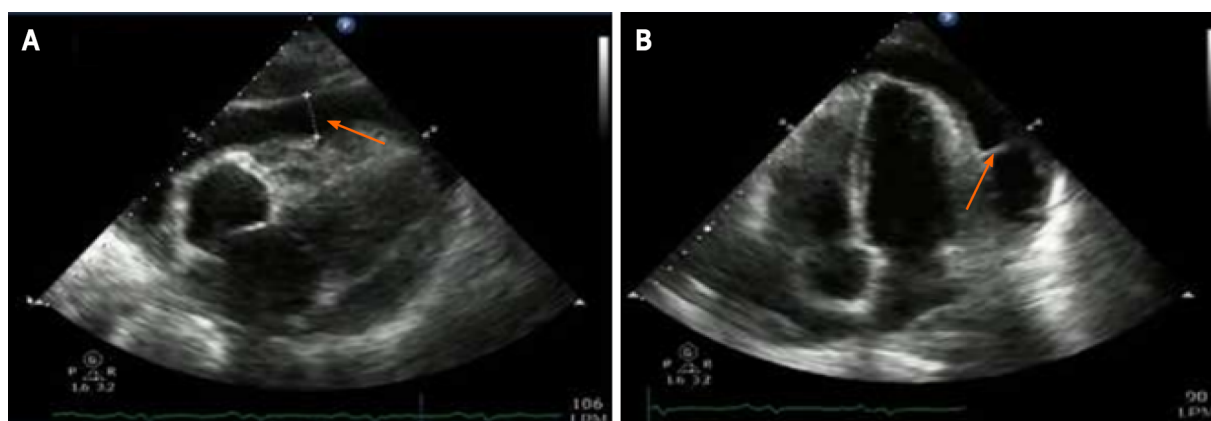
2D echocardiography. A: Echo-free space, or anechoic zone, between both layers of the pericardium of 27 mm (arrow) corresponding to pericardial effusion. The left ventricular ejection fraction was 60%, without segmental contractility disorders; B: Isoechoic image (arrow) at the level of the pericardial fluid that corresponds to a septum.
